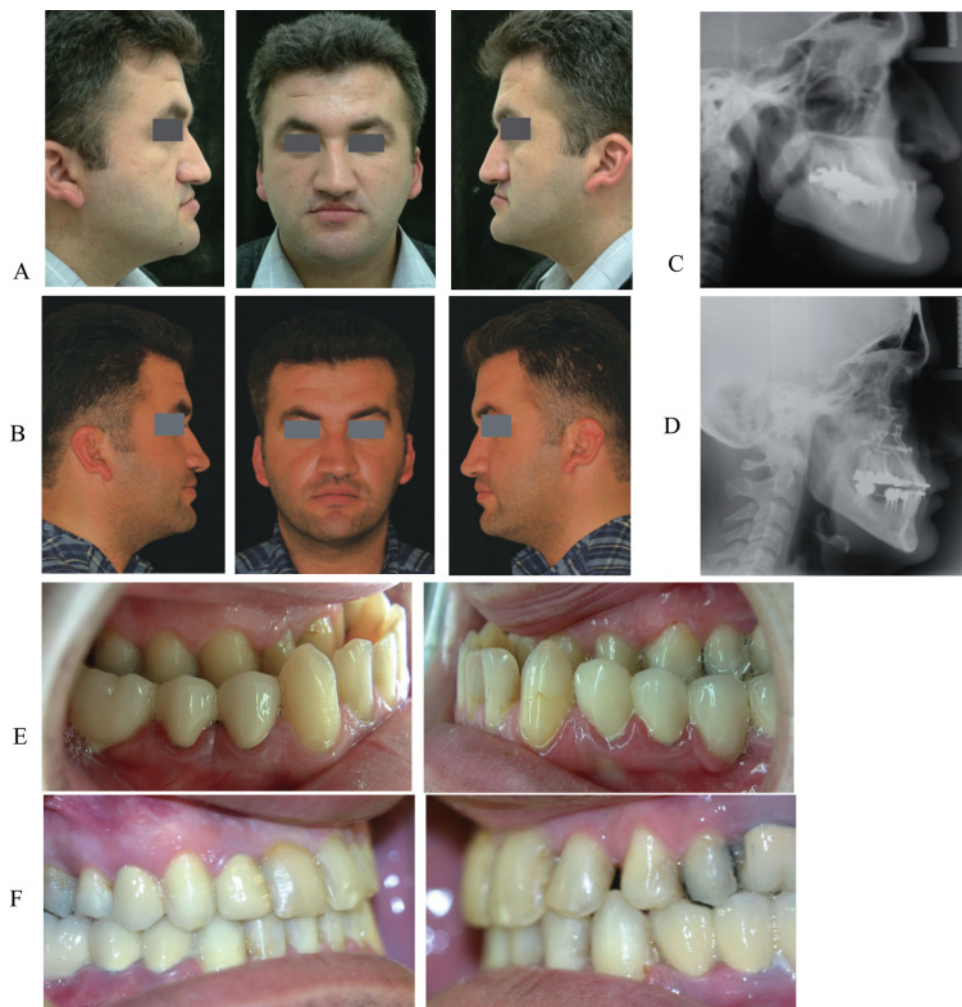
Pretreatment (A, C, E) and posttreatment (B, D, F) profiles, cephalographs, and occlusal views of man 30 years, 7 months old whose Class III malocclusion was treated with a combination of orthodontics and orthognathic surgery. X-ray reveals mandibular macrognathia and prognathism (C). Maxillary arch was entirely embedded within mandibular arch (E). Because of obtuse chin-throat angle (A), surgery was limited to maxillary advancement (8mm) and downward movement (4mm). Posttreatment profile (B), pre-debanding cephalograph (D), and posttreatment occlusion (F) reflect correction to Class I occlusion. Subsequent dental work was to include change of existing prostheses and aesthetic restoration of incisors.
